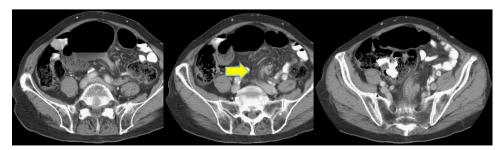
Selected images of computed tomography showing spiraled loops of collapsed bowel and mesentery which are twisted around their vascular supply, a "whirl" sign (arrow).
